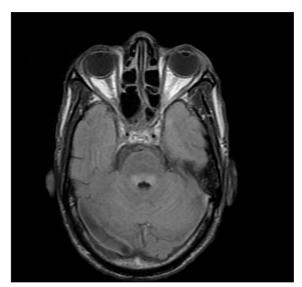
MRI scan case 2
